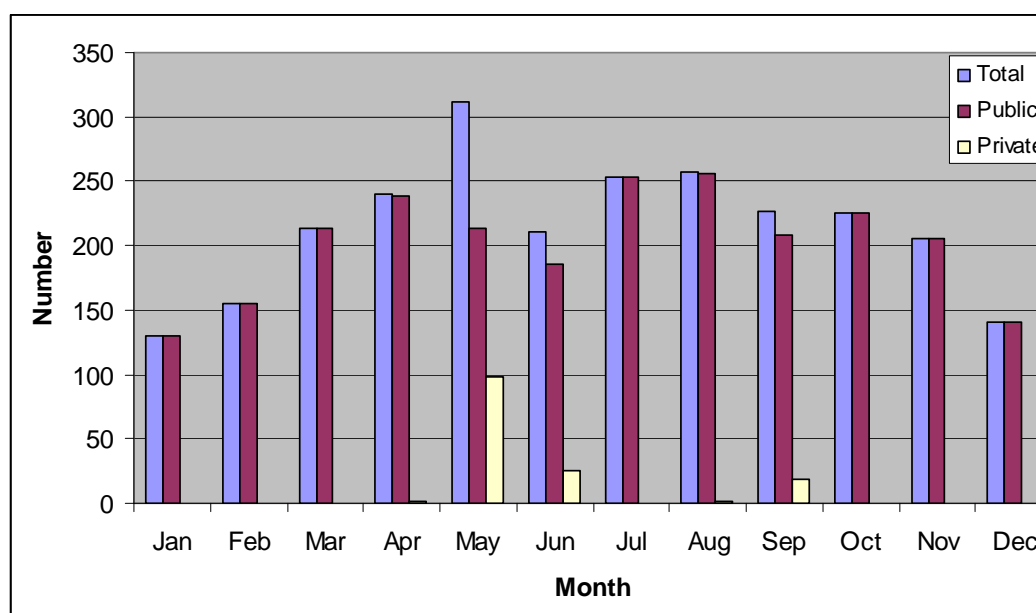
Chest X-rays performed during this period
